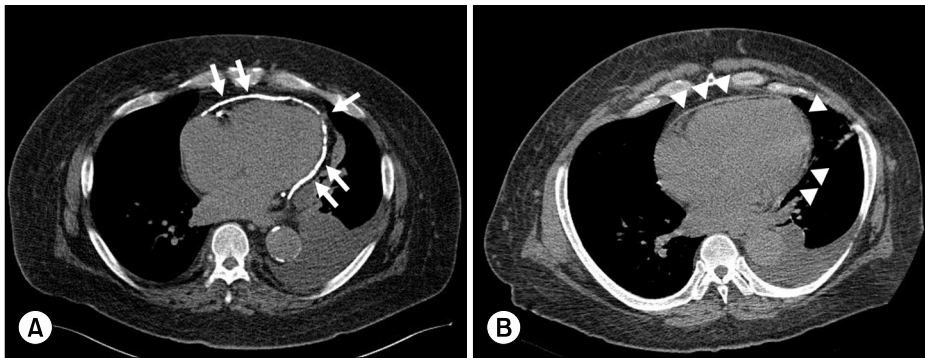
(A) Computed tomography (CT) revealing severely calcified pericardium (arrows). (B) An abdominal CT scan taken 11 years earlier showing pericardial thickening without calcification (arrowheads).
